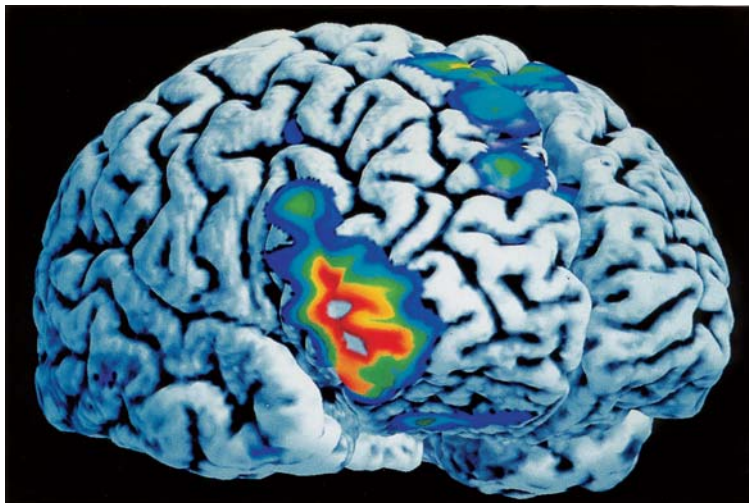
Superposition of magnetic resonance imaging (which shows the morphology of the brain) and positron emission tomography showing the active areas (coloured zones) in the brain. Courtesy of the Montréal Neurological Institute, McGill University
